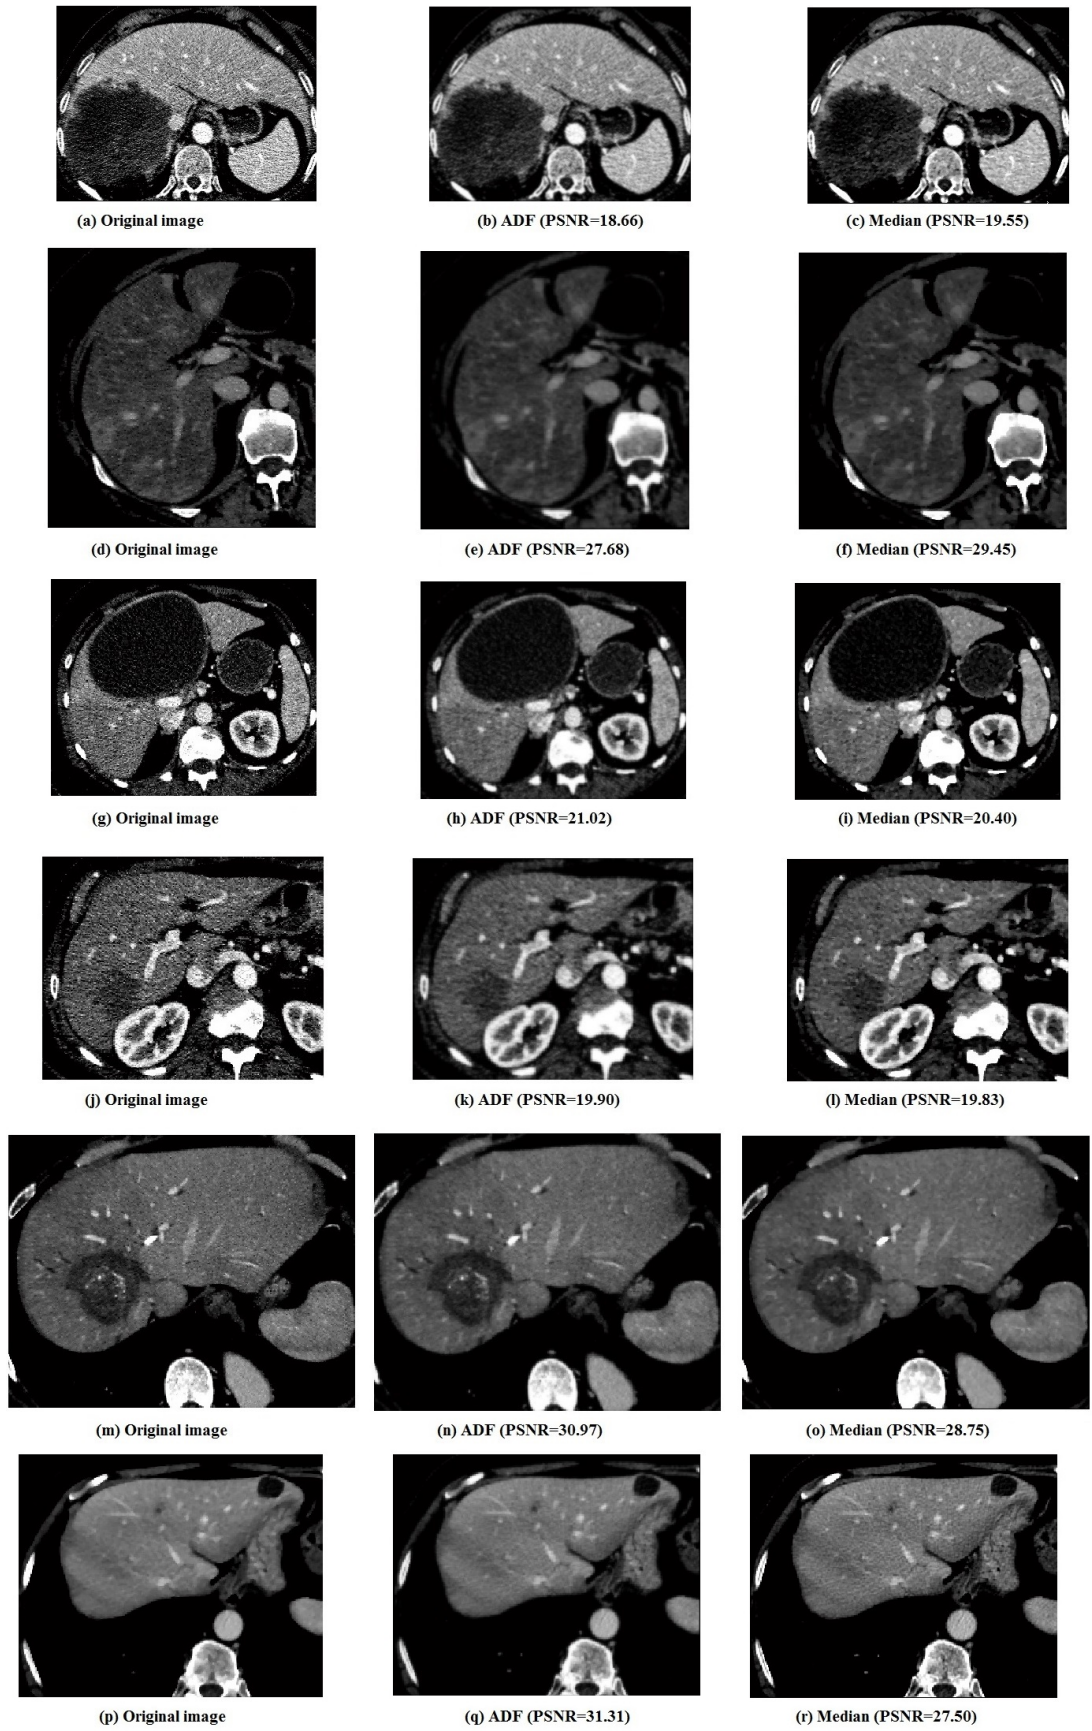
Pre-processing step to remove the CT image noise. (a, d, g, j, m, p) the original input CT image. (b, e, h, k, n, q) the output CT image after ADF. (c, f, i, l, o, r) the output CT image after median filter.
